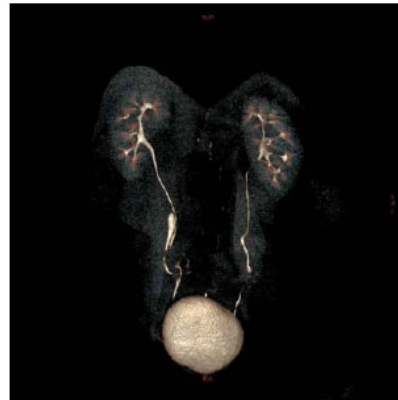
The three-dimensional reconstructed CT image in the excretory phase revealing the relationship between the ureteral diverticulum and the right ureter. The proximally blind-ending ureteral diverticulum joins the normal ureter at the distal end, immediately proximal to the ureterovesical junction.
